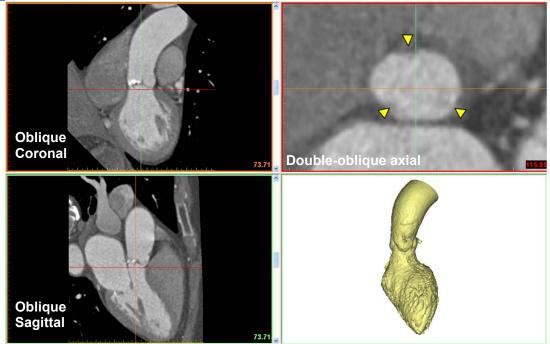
Figure CTA-3: Example images of reformatted oblique coronal (upper left), oblique sagittal (lower left), double oblique axial (upper right) and 3D reconstruction lower right. Yellow arrowheads indicate most caudal attachment of three leaflets of aortic valve.
